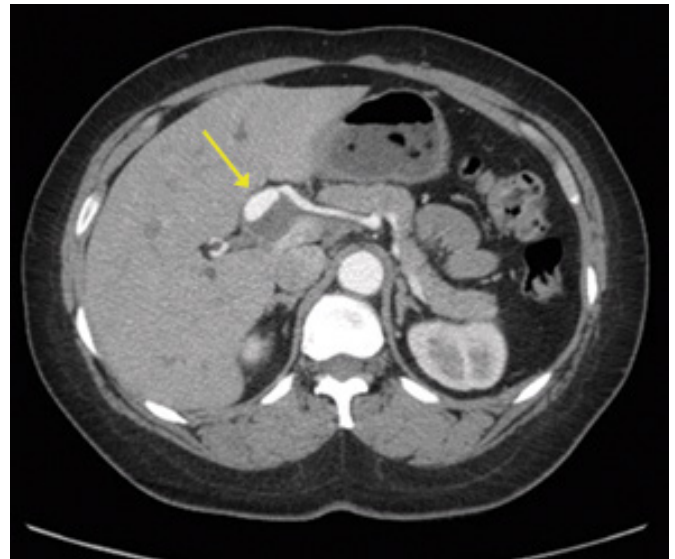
Coronal View of Hepatic Artery Aneurysm on CT. Published with Permission
